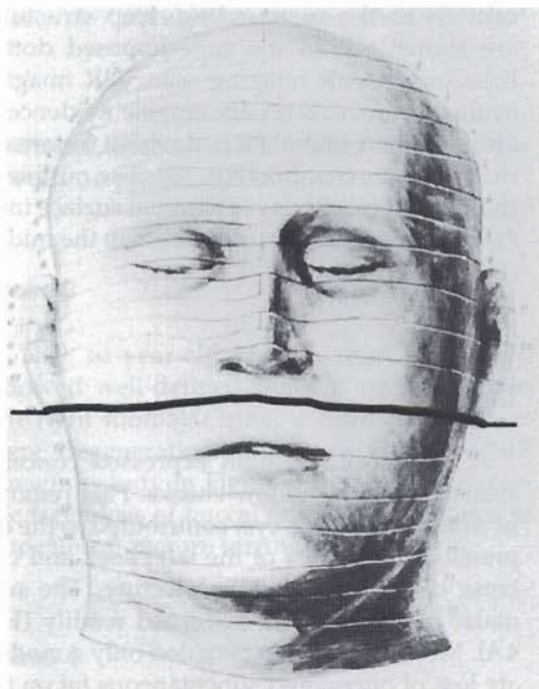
Level of the buccal fat pad (coronal plane). MR imaging scans were taken at this location in all patients to evaluate the consistency and volume of buccal fat.
